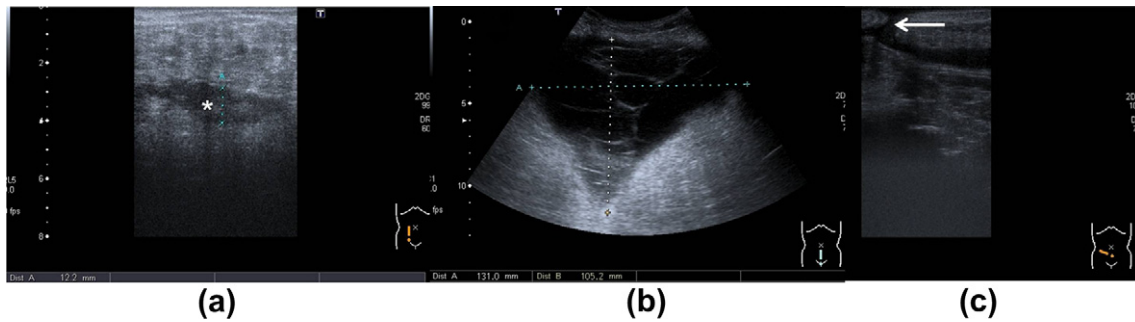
(a) High-frequency ultrasound image shows an abscess (asterisk) with surrounding inflammation. (b) Sagittal view in another patient shows a large, septated collection, and (c) a sinus track leading up to skin from an abdominal wall abscess (arrow).
